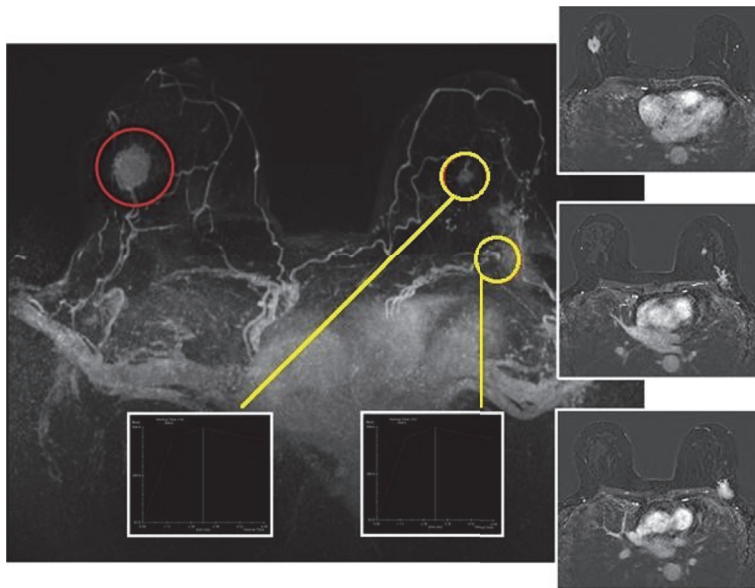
Index lesion (red circle; right IEQ, 30 mm), already documented with mammography and ultrasound. MRI leads to the detection of contralateral disease, confirmed to US second look and biopsy (yellow circle: left CEQ, 40 mm; left CEQ, 13 mm) (Inferior External Quadrant; IEQ: CEQ: Central External Quadrant).
